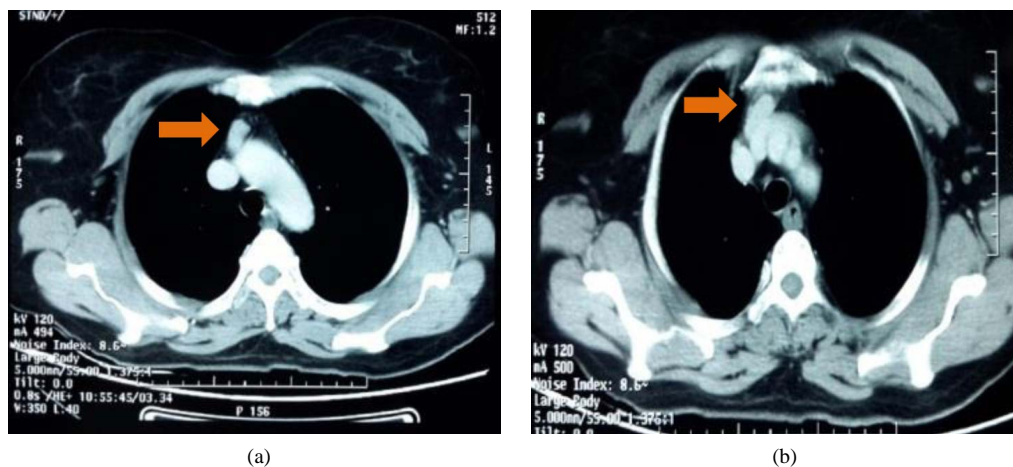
Chest CT showed a well defined soft tissue (red arrows) in the anterior mediastinum.
